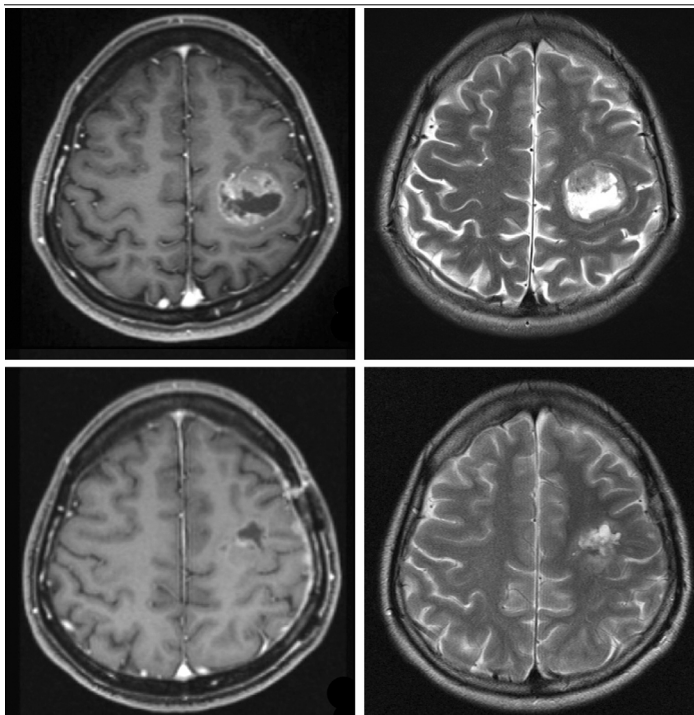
Magnetic resonance imaging (MRI) before initial operation showing the round ringed enhanced lesion in the left motor area without massive perifocal edema (upper). Postoperative MRI showing that the small remnant tumor left at the parietal side of removal cavity (lower).
